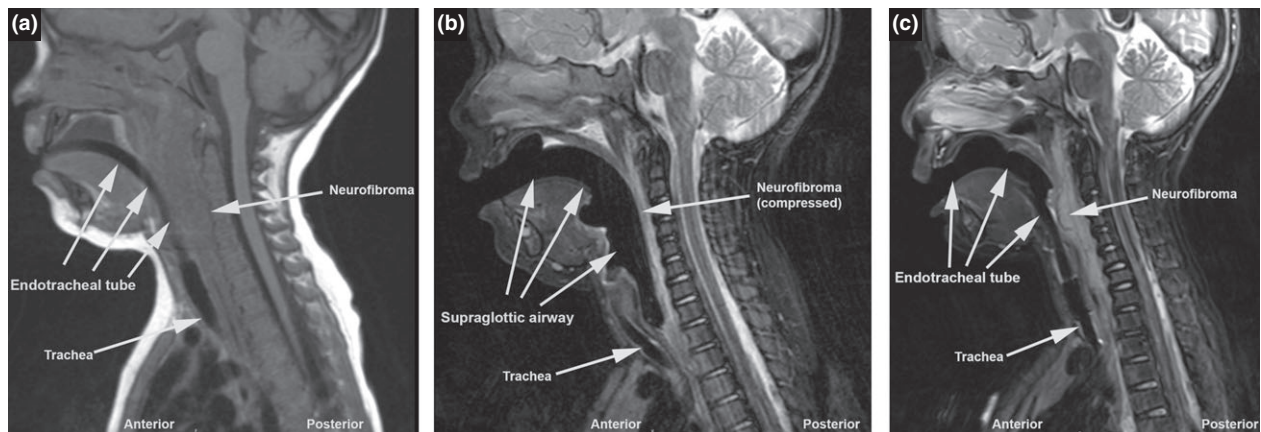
Sagittal images from three serial magnetic resonance imaging (MRI) studies to assess a 6-year-old child’s head and neck neurofibromas are shown. The child underwent general anesthesia and placement of an airway device for all three studies. Panel a shows the child’s 2011 MRI that was performed with an endotracheal tube (ETT). Panel b shows the use of a laryngeal mask airway during the child’s 2012 MRI. Panel c shows the child’s 2015 MRI during which an ETT was used. All three MRI images are oriented with the child’s anterior on the left and posterior on the right. Arrows point to the airway device (ETT or laryngeal mask airway) as well as the child’s trachea and precervical neurofibroma in all three images.
